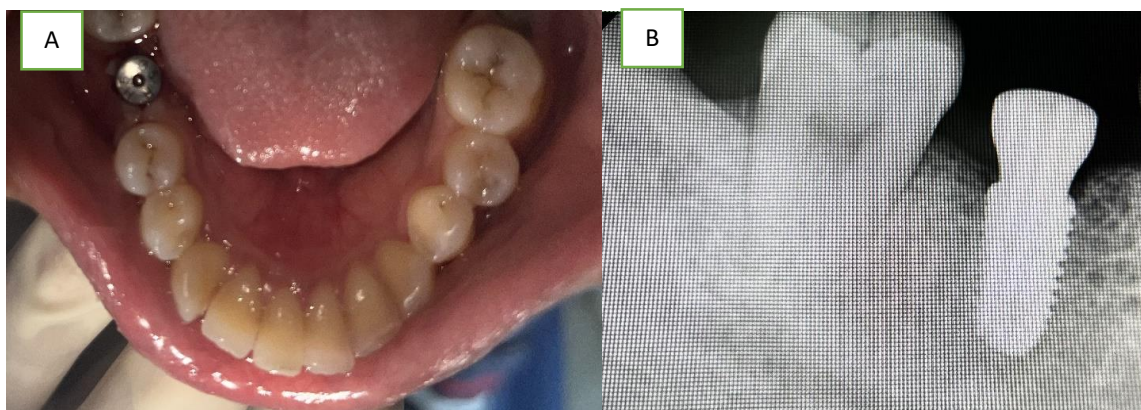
A) Healing abutment in place A) on clinical examination B) in intraoral periapical radiograph
